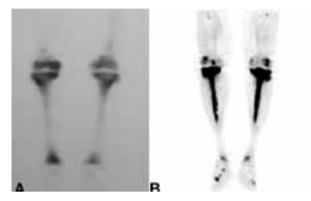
2AB. (A) Bone scan and (B) PET-CT of a patient with ECD show symmetrically increased uptake at the distal ends of the femurs and the proximal and middle tibia
